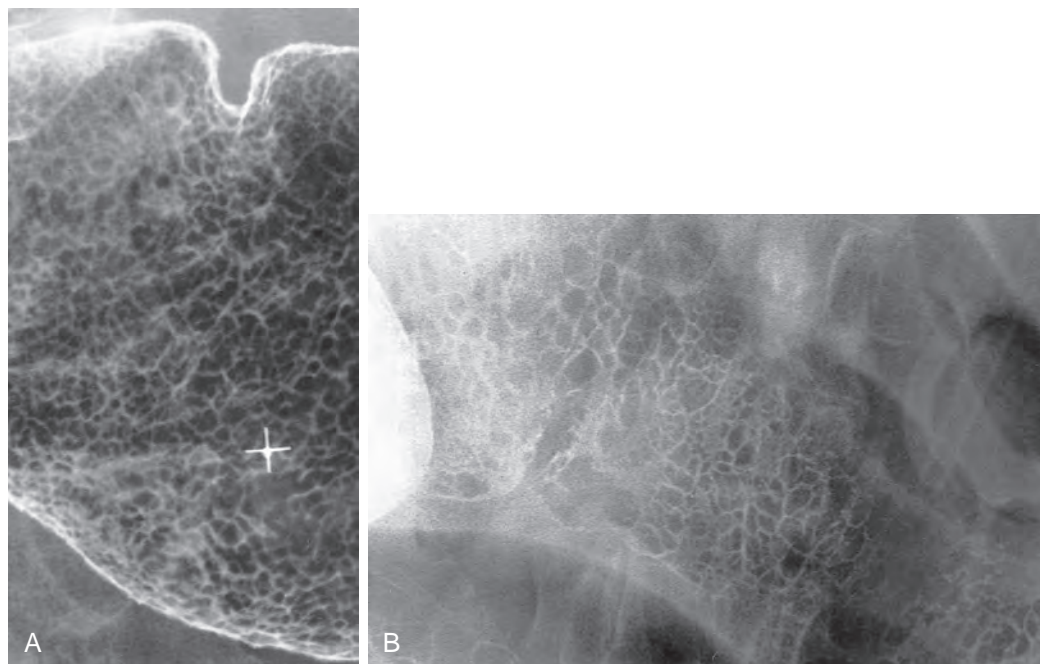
Reticular pattern. A. Areae gastricae. In general, columnar mucosa in the gastrointestinal tract is divided into islands of tissue surrounded by shallow grooves. This pattern is best exemplified in the areae gastricae of the stomach. The areae gastricae are seen as well-circumscribed, polygonal radiolucencies surrounded by barium-filled grooves. B. Urticarial pattern in the colon. When colonic mucosa is slightly elevated by edema and/or mild inflammation, the colonic surface may assume a reticular pattern. Barium etches sharply polygonal epithelial islands. This has been termed an *urticarial pattern* because it was first described in colonic urticaria. However, any disease that causes mild edema, inflammation, or ischemia of the mucosa may cause the columnar mucosa of the colon to assume an urticarial pattern, including ischemia caused by obstruction or adynamic ileus or inflammation caused by a viral infection. (B from Rubesin SE, Saul SH, Laufer I, et al: *Carpet lesions of the colon*. *RadioGraphics* 5:537–552, 1985.)
